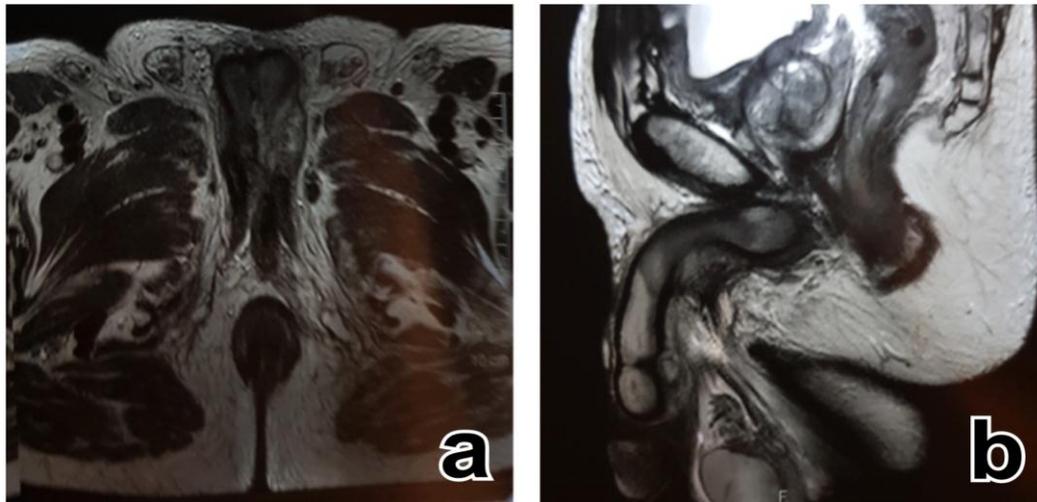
Axial magnetic resonance image (a); and sagittal image (b) T1-weighted, showing a heterogeneously bulbomembranous tumor replacing the urethra.
